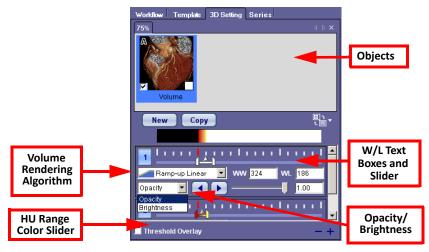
3D Settings on Image Having Bone and CT Table Removed
